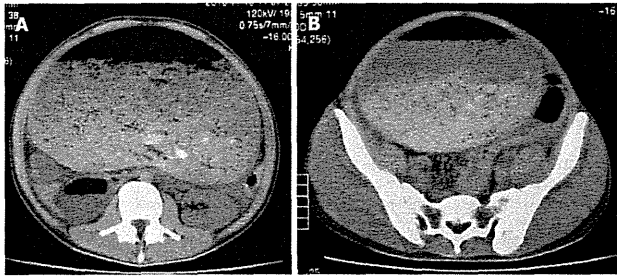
Computed tomography on initial admission. A. Upper abdomen B. Pelvis.
